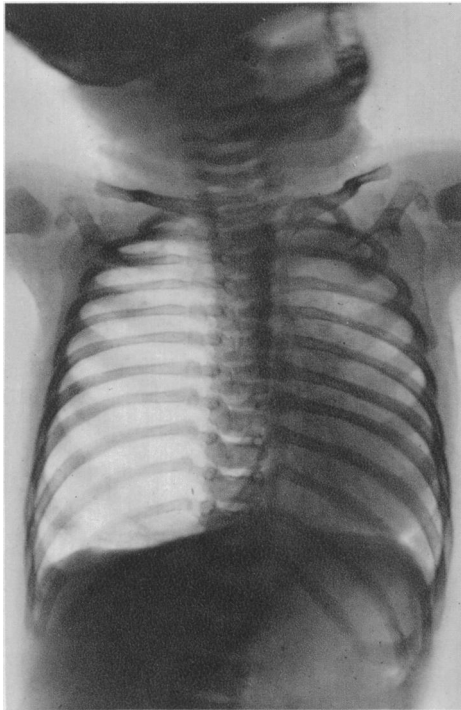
Radiograph showing the pulmonary remains at the apex and the base. August 13, 1936.
